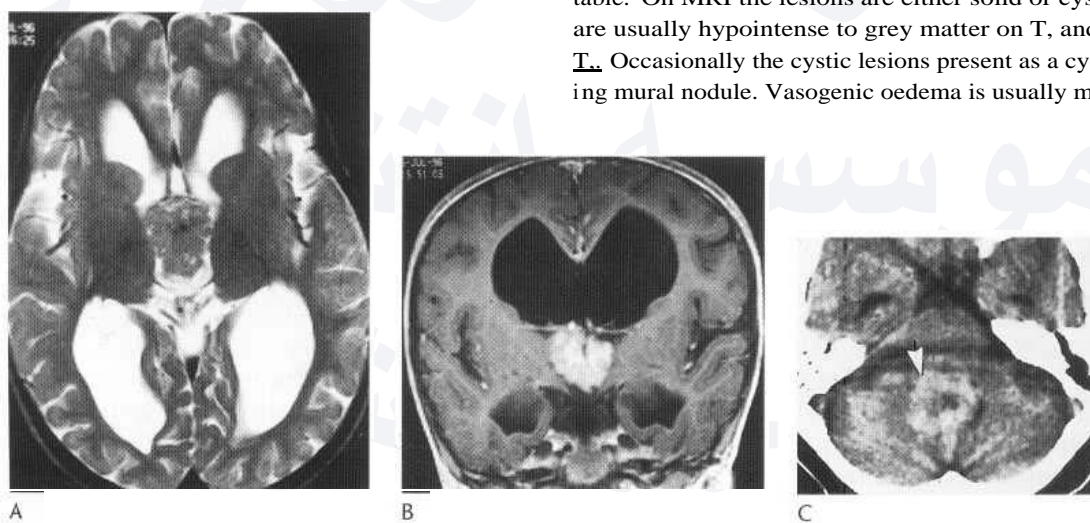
Axial T₂-weighted image (A,B) showing a lobulated vascular mass within the third ventricle which shows avid uniform enhancement on the coronal postcontrast T₁-weighted image and is consistent with a choroid plexus papilloma. The lateral ventricles are markedly dilated due to obstructive hydrocephalus. (C) CT shows a rounded mass of increased attenuation with a low-density centre occupying the fourth ventricle. (D) After contrast medium, a slightly higher section shows strong uniform enhancement.
